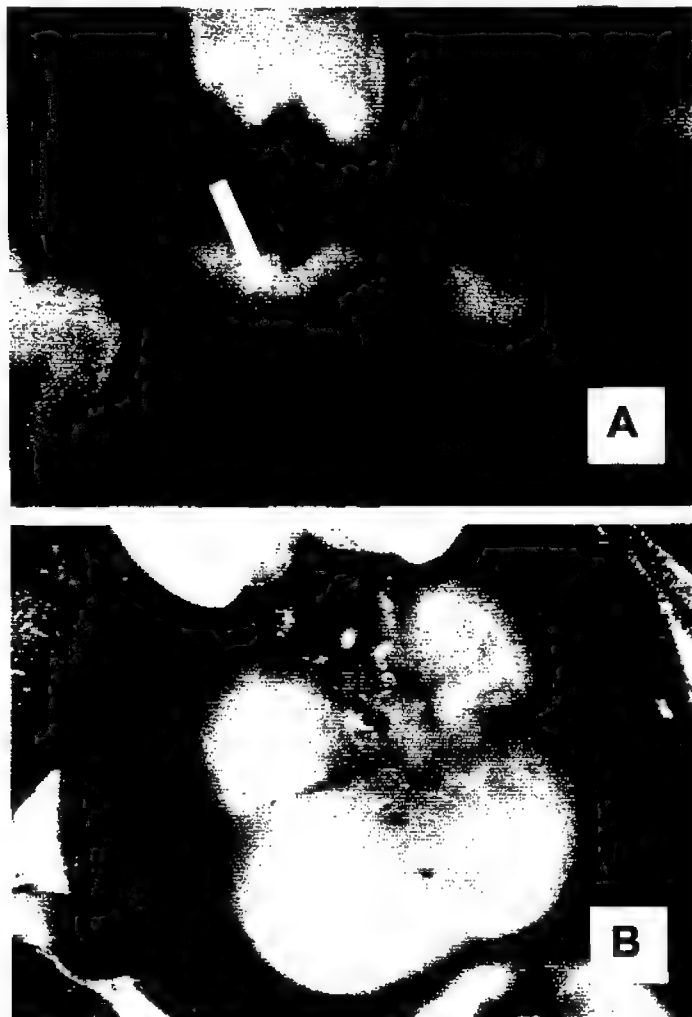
Occlusal dentine radiolucency on a bitewing radiograph (A, *arrow*) of a clinically intact sealed mandibular second permanent molar (B).
